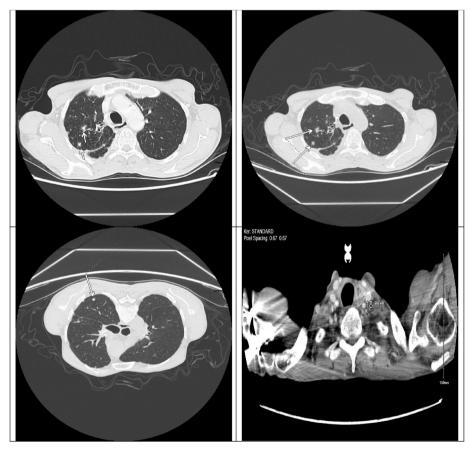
1 year follow-up CT scans demonstrated a further reduction in the size of the right apical cavitary lesion, which then stabilized without significant changes.
